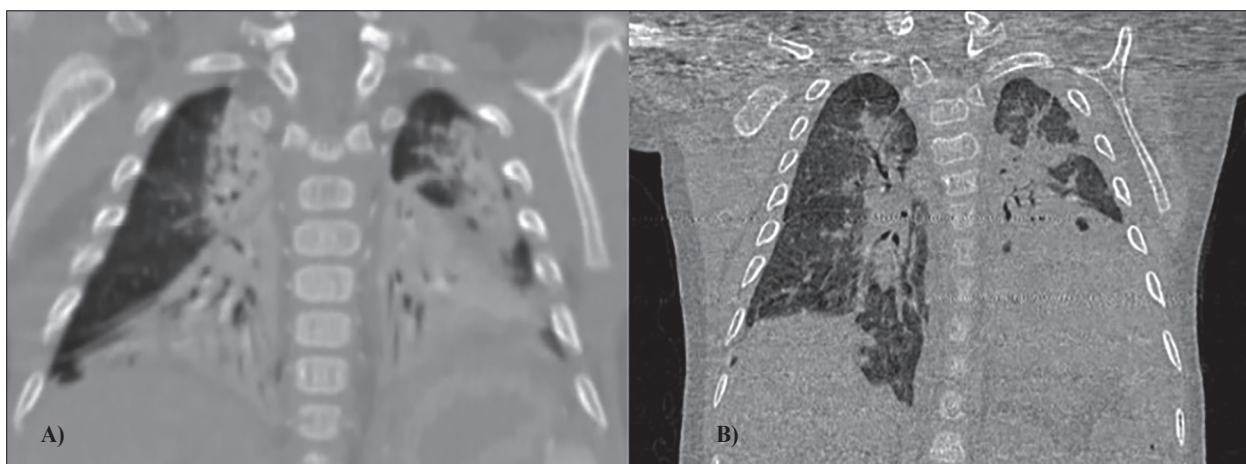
Chest CT scan. A) Initial finding – consolidations, intralobular thickening and mirror ground-glass opacifications. B) A follow up CT scan six months later – bilateral consolidations with fibroindurative lesion or plate-like atelectasis, and mild septal thickening.
